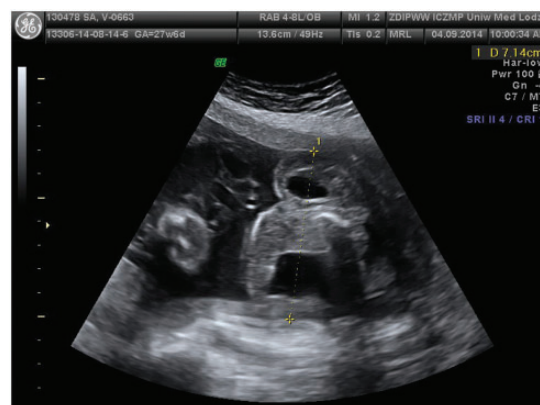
Ultrasound scan at 27th week of gestation showing a tumour diameter over 7 cm and tumour mass resembling brain tissue.
